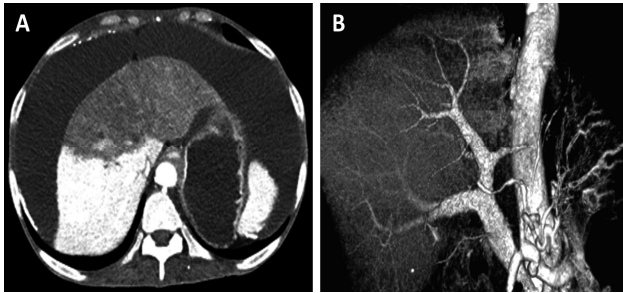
Further liver imaging. (A) Abdominal CT shows infarction of the left lobe of the liver and massive ascites. The patient's EPS can be visualized, with no significant difference compared to previous CT findings. (B) Reconstructed angiography shows diffuse narrowing of the left hepatic artery and branch of the left portal vein with non-visualization of the left lobe, suggesting a liver infarction.
